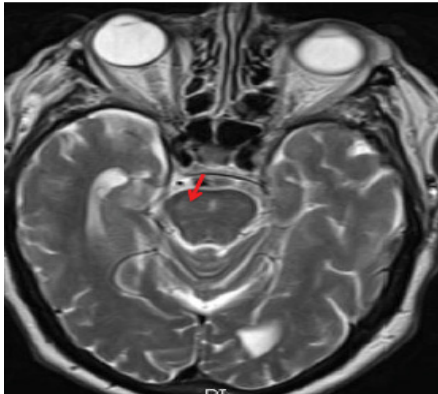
T2 MRI sequence 48 hours after stroke onset demonstrating only small area of faint hyperintensity in the L paramedian pons.
